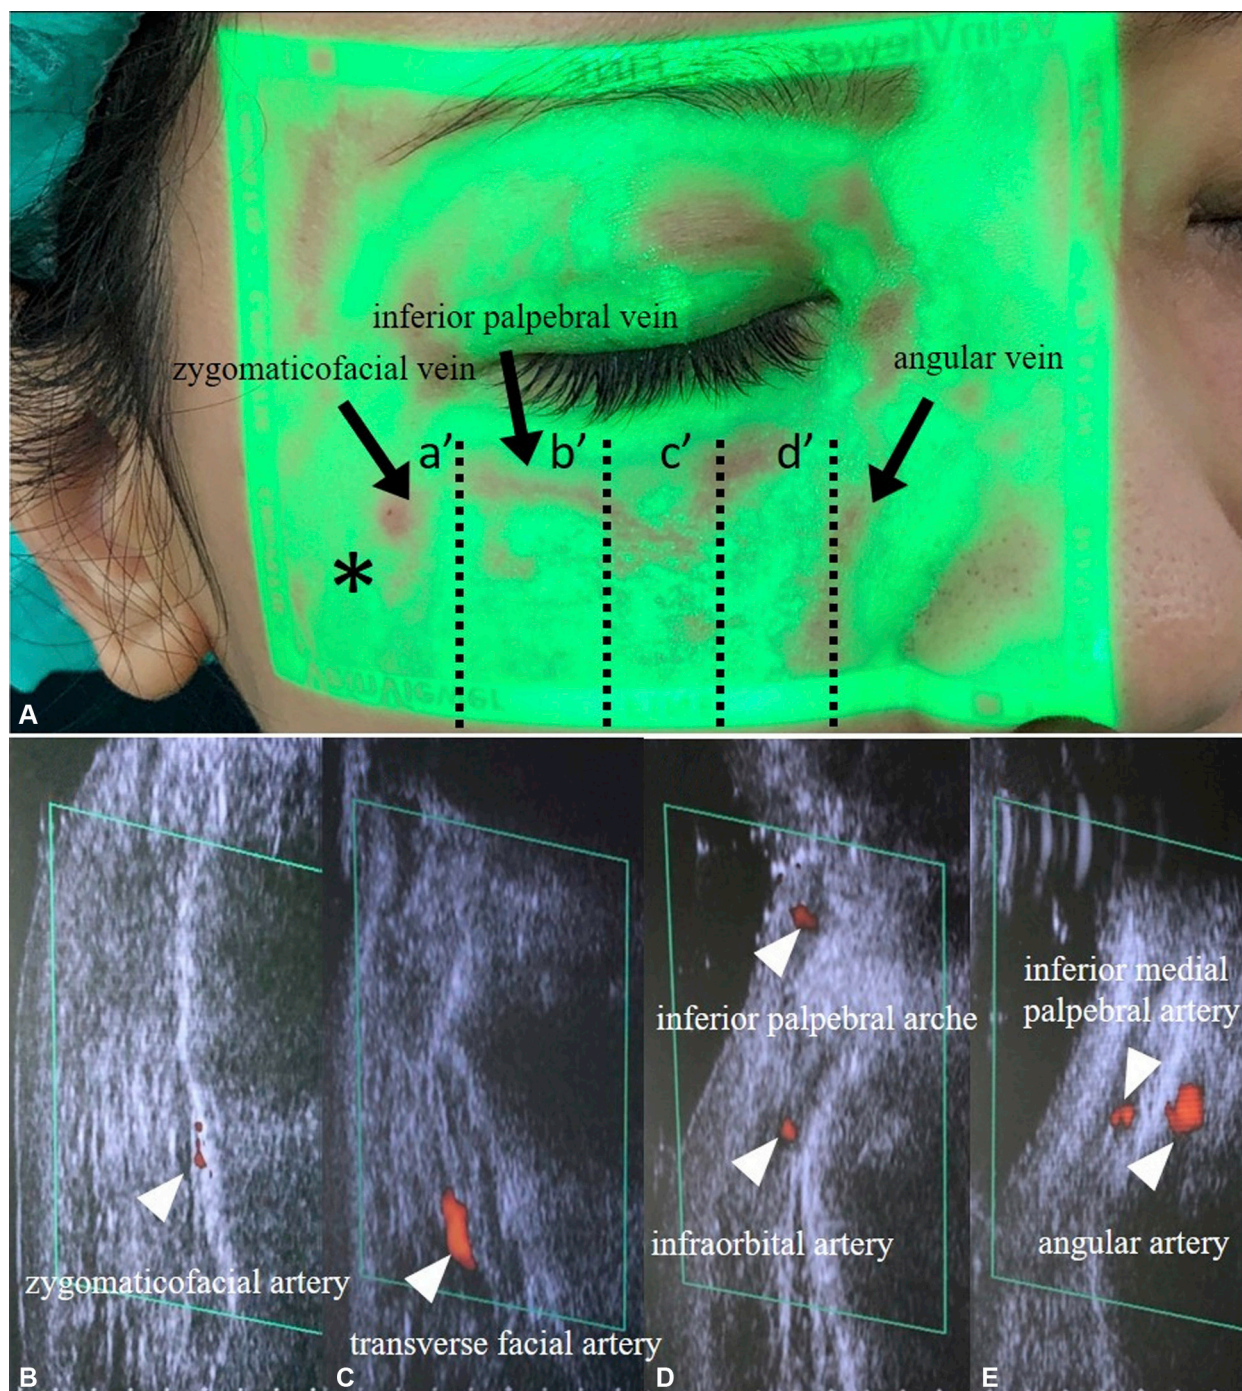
A, The Vein Viewer (Christie Medical Holdings, Inc, Memphis, TN) was used to detect the distribution of superficial veins and to choose the entry point (asterisk). Serial ultrasonographic examination with color Doppler was performed on dotted lines (a'-d') to detect sagittal anatomy of the treated area. B, Ultrasonography of dotted line a'. C, Ultrasonography of dotted line b'. D, Ultrasonography of dotted line c'. E, Ultrasonography of dotted line d'.
